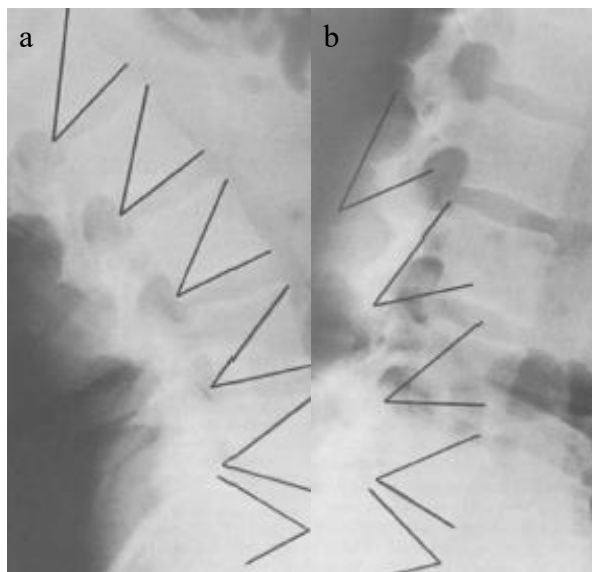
Kinematic measurement technique: (a) Roentgenogram in sagittal plane in flexed position, (b) Roentgenogram in sagittal plane in extended position (Hanley et al., 1976).
